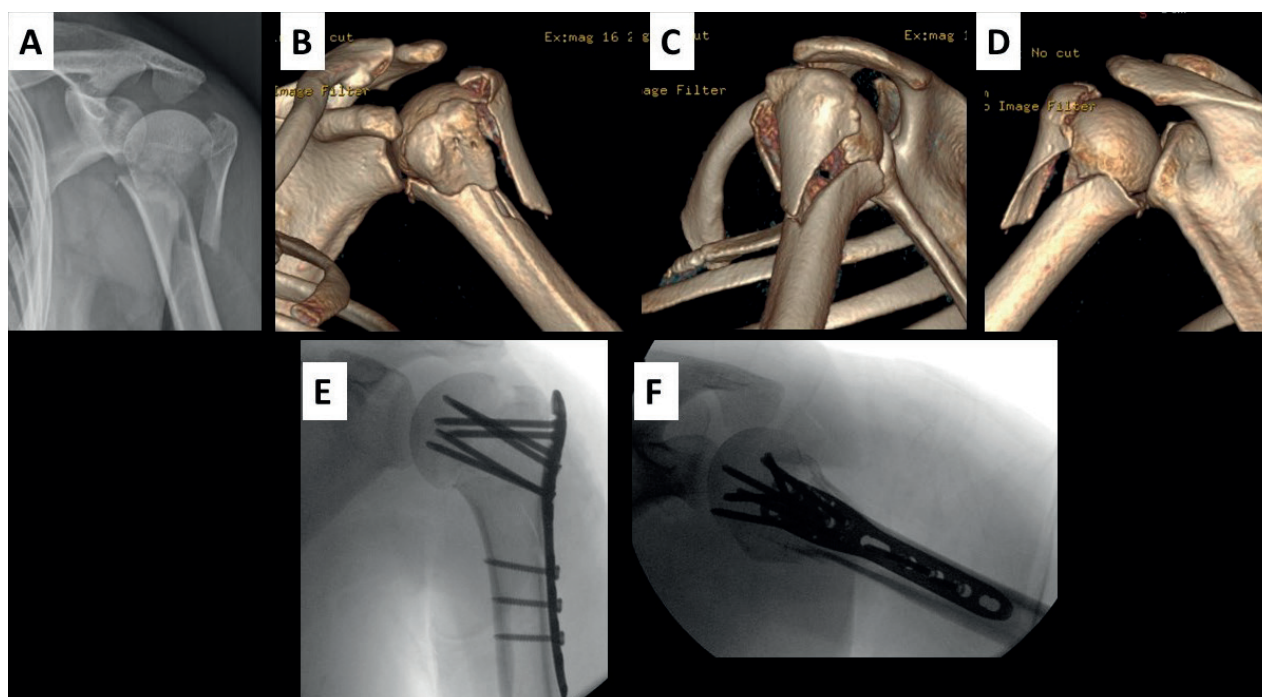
Clinical case 2: Female, 67 years old. Proximal humeral fractures Neer 4 treated by ORIF using direct lateral transdeltoid approach (LTA). (A) Preoperative AP view X-Rays (XR); (B-D) 3D CT-scan Anterior/Lateral/Posterior view; (E-F) postoperative AP and LL X-Ray. The restoration of the humeral head-shaft angle was obtained in combination with a good reduction of the humeral greater tuberosity.
